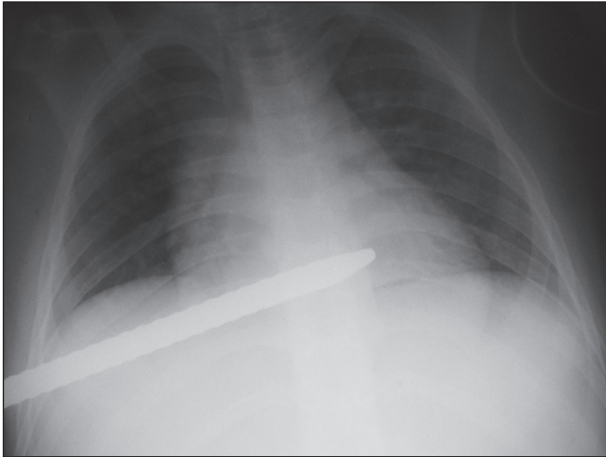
Posteroanterior chest radiograph of a patient stabbed with a metal bar into his right hemithorax
